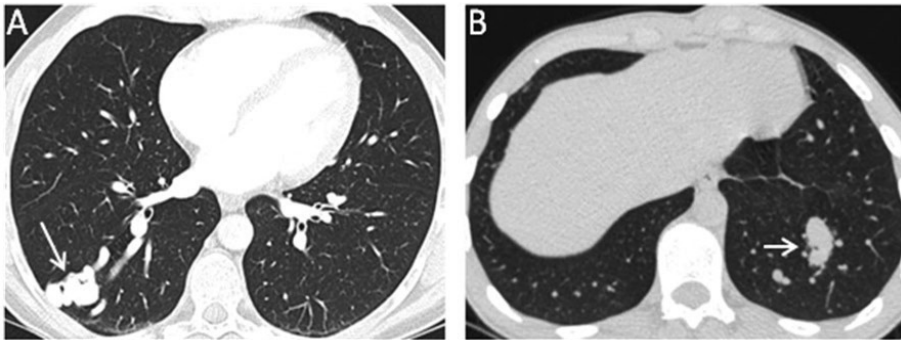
Examples of PAVMs on chest CT; A: Large PAVM (arrow) peripherally in the right lower lobe; B: Large PAVM (arrow) in the left lower lobe.
